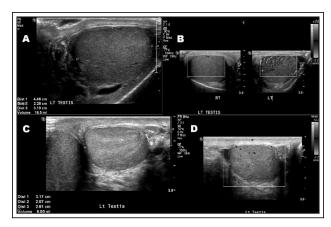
Scrotal ultrasound scans demonstrating the change in left testis size and vascularity. Note: A and B, initial ultrasound showing left epididymo-orchitis; C and D, subsequent ultrasound showing a smaller and relatively hypovascular left testis.
